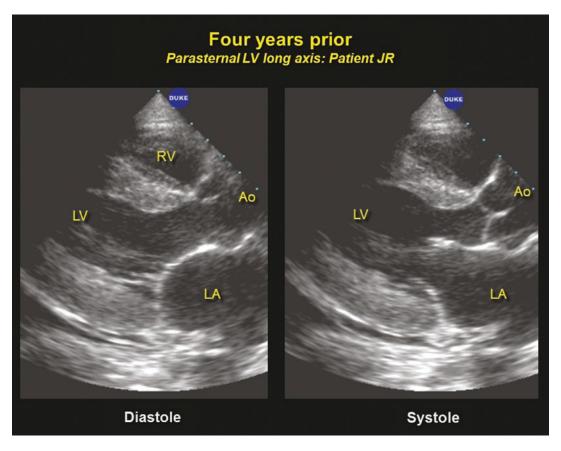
Echocardiogram performed 4 years earlier on the patient seen in Fig. 10.121. No vegetative masses were seen then
